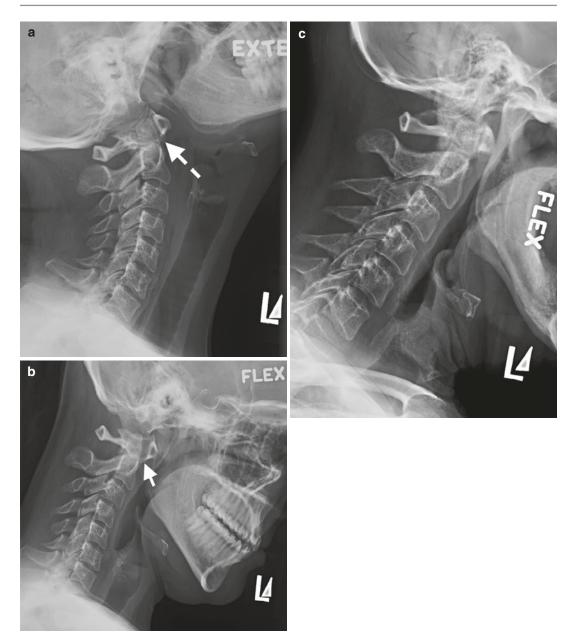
Lateral cervical spine radiographs showing atlantoaxial instability in a 75-year-old woman with long-standing RA in a routine pre-op assessment, (a) in extension with normal atlantoaxial interval (*dashed arrow*)
